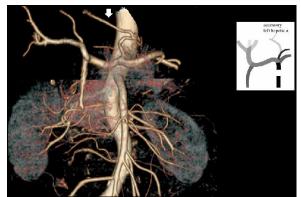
A 3D reconstructed image of CT angiogram of a 46-year-old female showing accessory left hepatic artery arising from left
